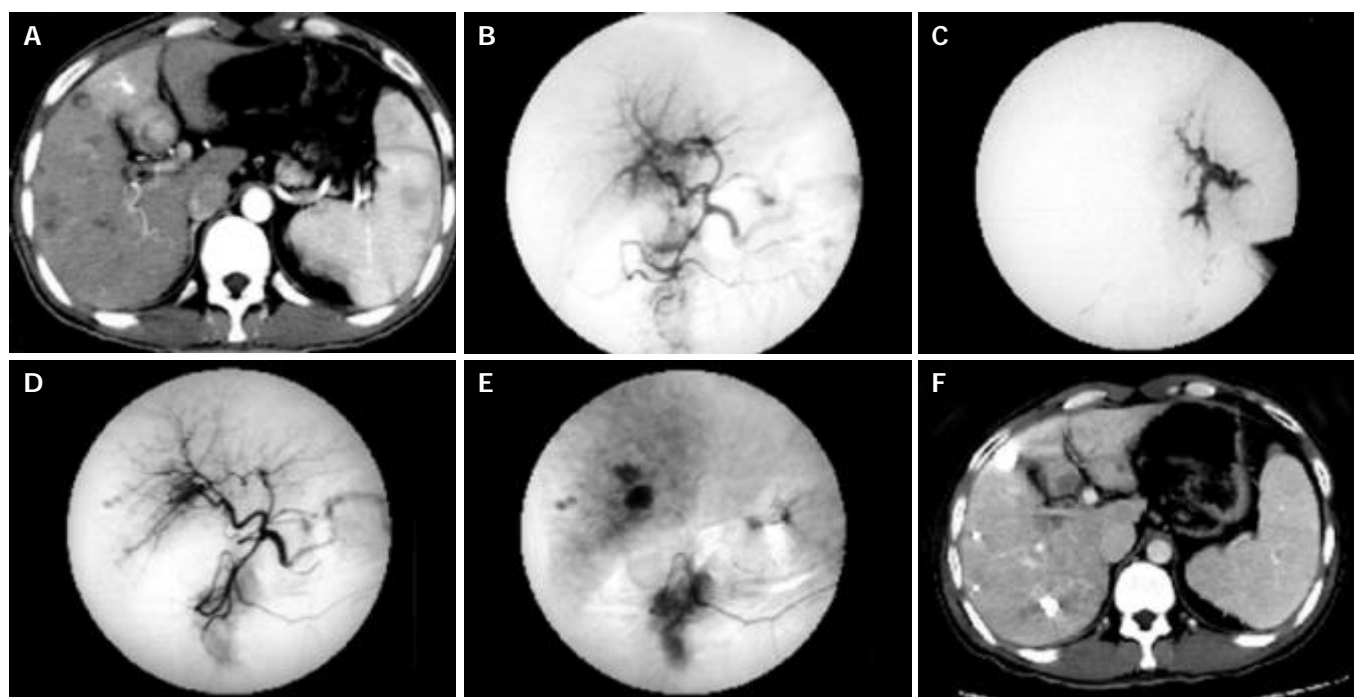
Multiple HCC nodules in a 34-year-old patient. A: CT image obtained during the arterial phase showed the predominant enhancement of the medial segment of left lobe and the enhancement of left portal branches, which represent APS. B: Hepatic arteriogram demonstrated the arterioportal shunt. C: The microcatheter was inserted into the feeding artery of APS. DSA showed the strong or fast blood flow of APS. D-E: Hepatic arteriogram showed that the arterioportal shunt was no longer visible after embolization with a microcoil and ethanol. F: Follow-up CT scan showed lipiodol accumulation in multiple HCC nodules, and liver necrosis was not seen in the distribution of the hepatic artery which had been treated with ethanol.
